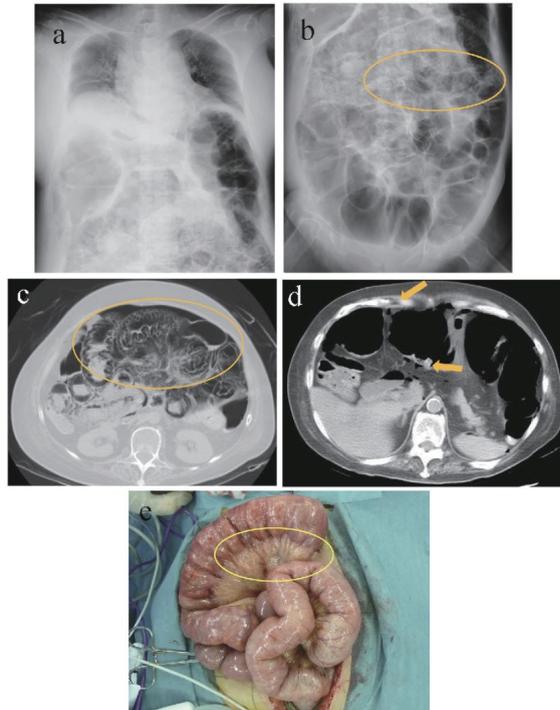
A chest radiography revealed elevation of the diaphragm due to dilated and gaseous intestines (a). A radiograph of the abdomen revealed diffusely dilated intestines and multiple, small radiolucent linear bubbles lining the intestines (circle) (b). Abdominal computed tomography revealed dilated and gaseous small intestines, retention of gas in the intestinal wall (circle) (c), and intraperitoneal free air (arrows) (d). Operative findings revealed small air bubbles in the intestinal wall and mesentery (e).
